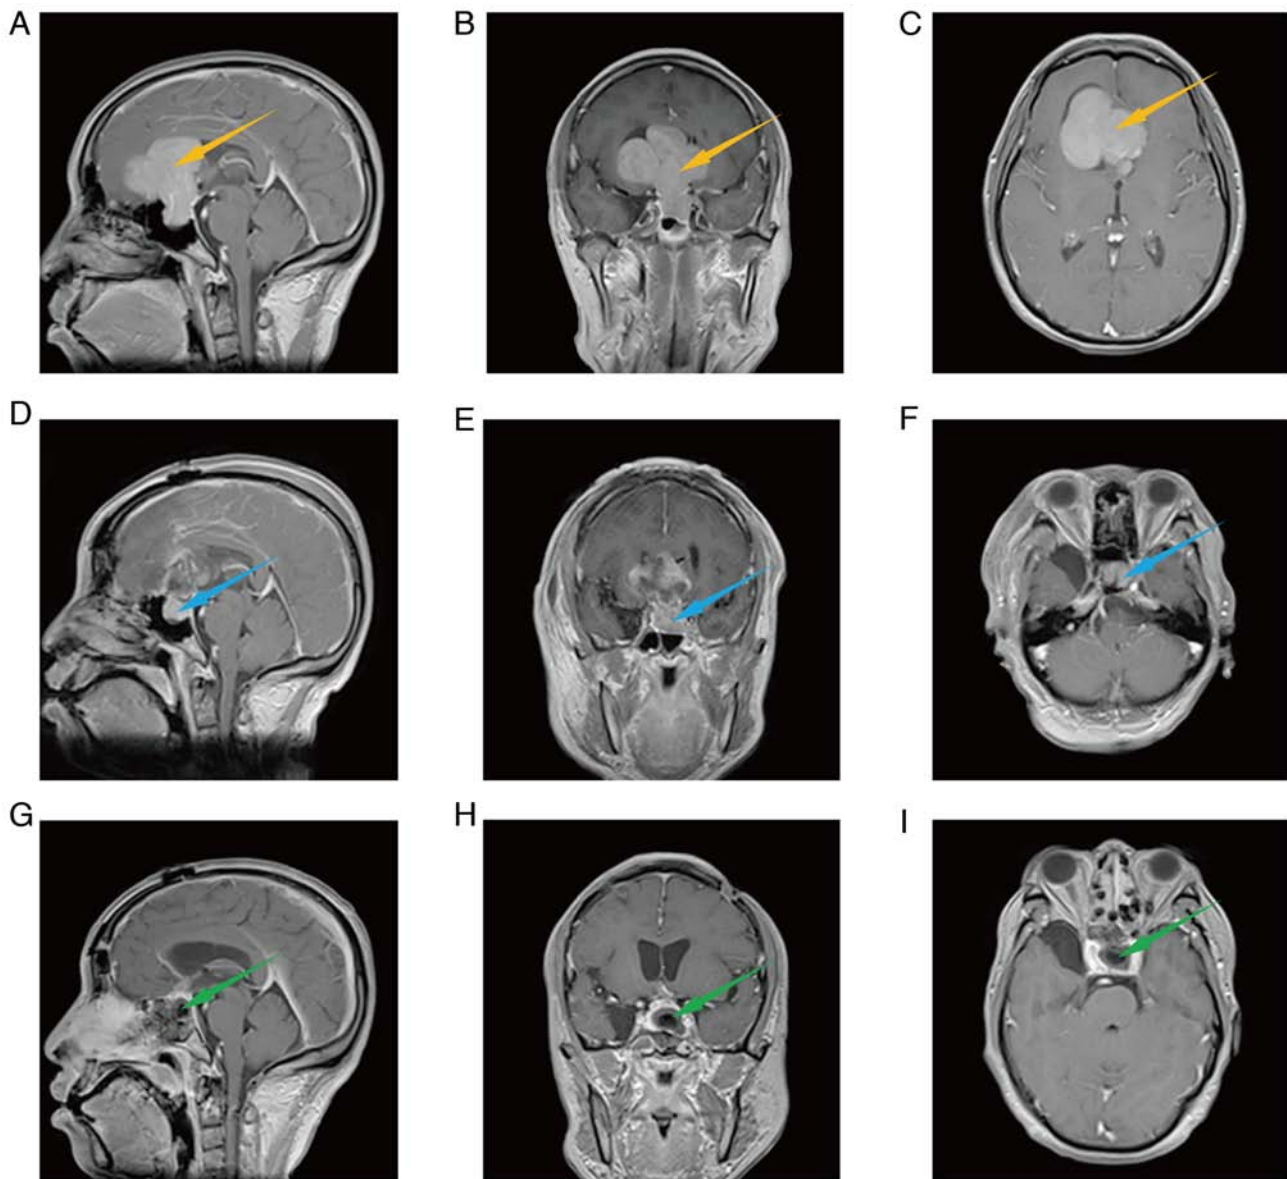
Preoperative and postoperative gadolinium-enhanced T1-weighted cranial MRI of case 1. The (A) sagittal, (B) coronal and (C) transverse views of the preoperative MRI. The (D) sagittal, (E) coronal (F) and transverse views of the MRI after the first-stage operation. The (G) sagittal, (H) coronal and (I) transverse views of the MRI after the second-stage operation. The yellow, blue and green arrows indicate a preoperative tumor, residual tumor and tumor cavity, respectively.
